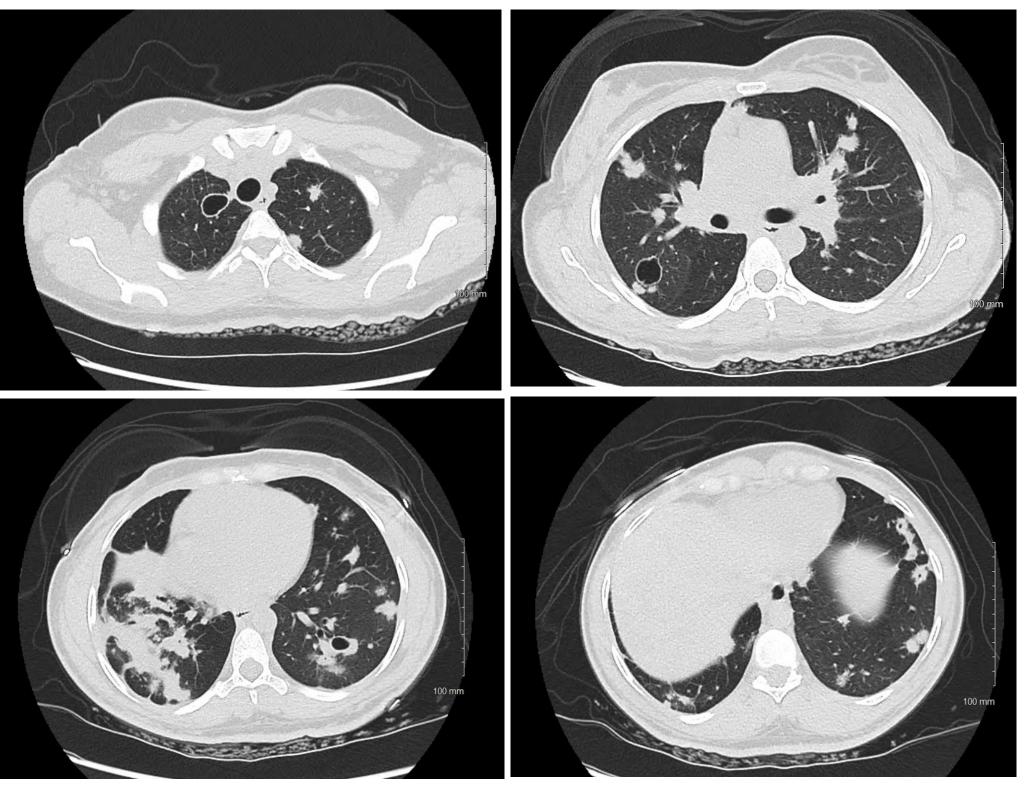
HRCT Chest showed bilateral multifocal nodular and cavitary lesions, mediastinal and hilar lymphadenopathy, with right lower lobe consolidation
